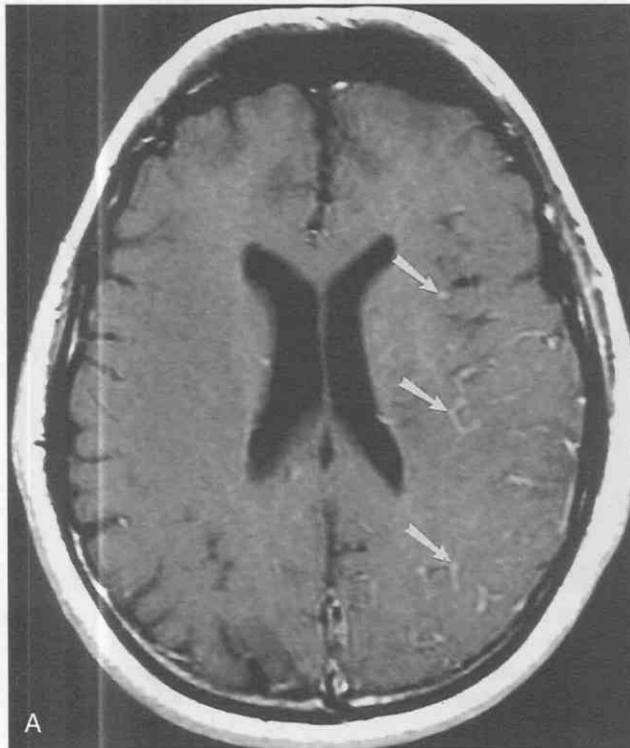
Acute right-sided weakness. *A*, T1-weighted axial image following intravenous gadolinium (0.1 mmol/kg) shows prominent intravascular enhancement (*arrows*). *B*, T1 postcontrast coronal image shows asymmetrical enhancement of the left tentorium (*small arrows*). *C*, T2-weighted axial image shows high signal in the territory of the left middle cerebral artery (inferior division), consistent with infarction.
